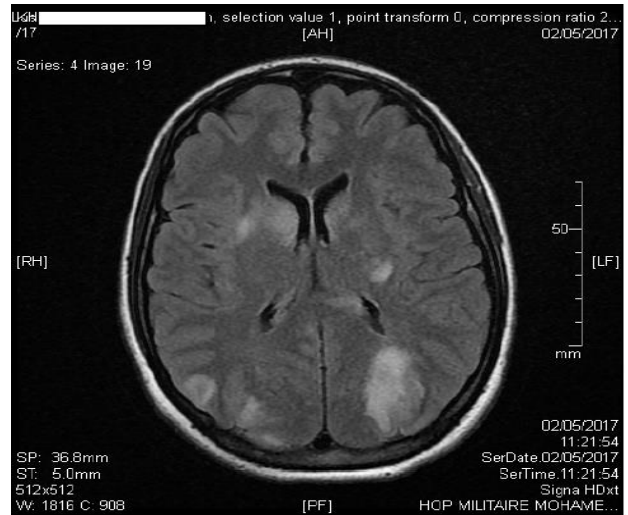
Brain MRI, axial section, FLAIR sequence: Bilateral and asymmetric cortico-subcortical hypersignals, in parietal, capsulo-lenticular and caudate nuclei heads.
